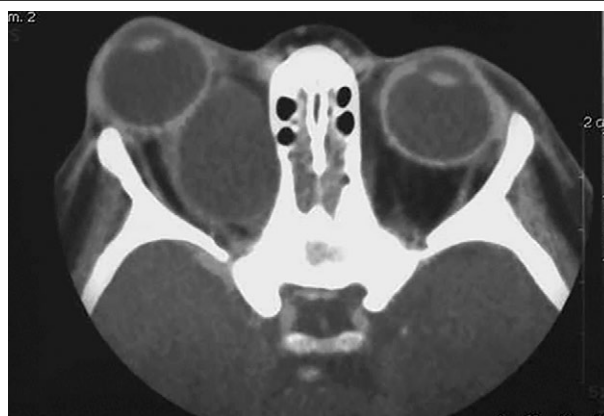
Orbital hydatid cyst type I Gharbi's classification. An 18-year-old boy presented with progressive right eye swelling and visual deterioration: axial contrast CT scan shows a well-demarcated intraconal cystic lesion, located in the posterosuperior region of right bulbous oculi. Note the mass effect on the optic nerve. Orbital hydatid cysts generally occur in a posterior position.
